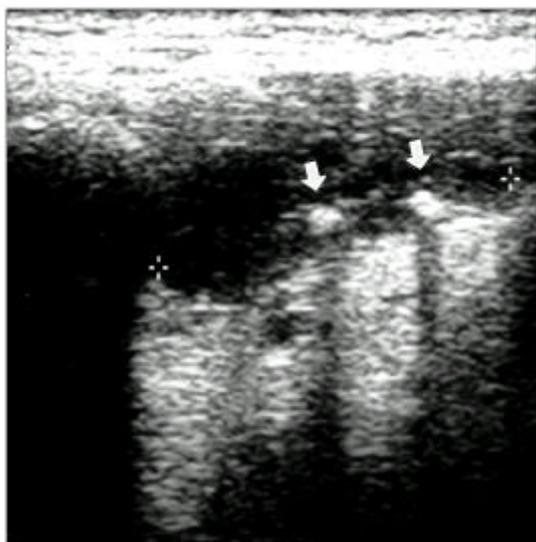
Neck ultrasonography shows two high acoustic densities with posterior acoustic shadow (arrow).
